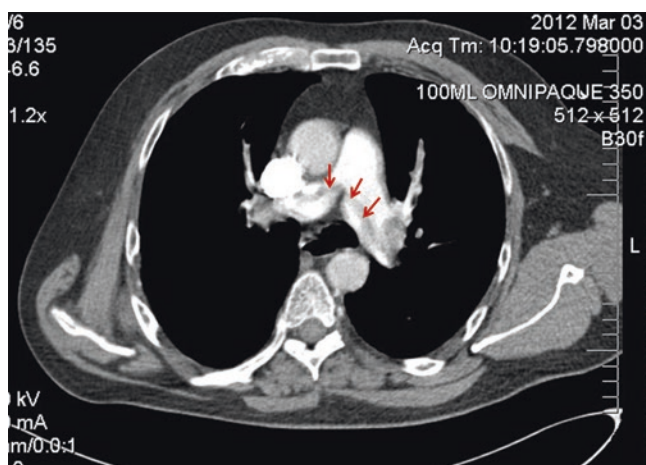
Saddle pulmonary embolus (arrows) on computed tomography scanning with intravenous contrast. (Figure courtesy of T. Metkus, M.D.)
